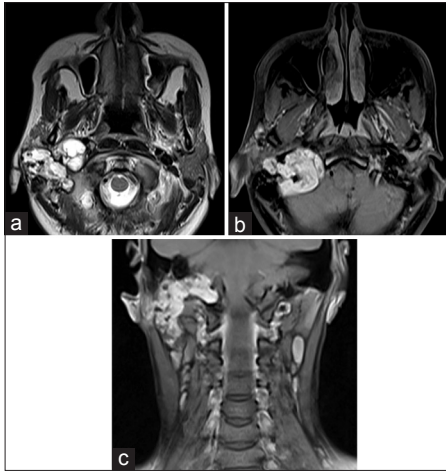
(a) Axial T2, (b) axial postcontrast T1 and (c) coronal T2-weighted magnetic resonance images reveal a heterogeneously enhancing mass in the right mastoid air cells extending medially along the floor of the posterior fossa and abutting the right cerebellar hemisphere
